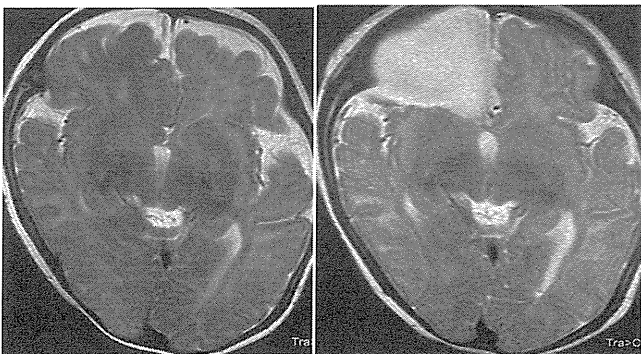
Lobar resection indicated for a frontal lobe CD. All MRI-visible lesions in front of the nucleus accumbens at the line connecting the bottom of peri-insular sulcus, limen insulae, and subcallosal area were completely resected. Left panel: pre-op. Right panel: post-op.
